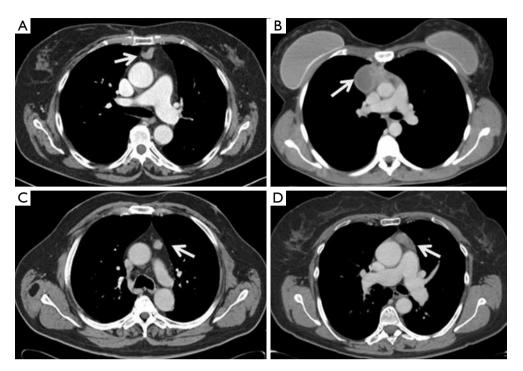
CT scans of: (A) small thymoma centrally located (white arrow) and surrounded by perithymic fatty tissue; (B) cystic thymoma (white arrow) with unilateral predominance on the right side; (C) small thymoma (white arrow) with unilateral left predominance and surrounded by perithymic fatty tissue; (D) thymoma (white arrow) with unilateral left predominance.
